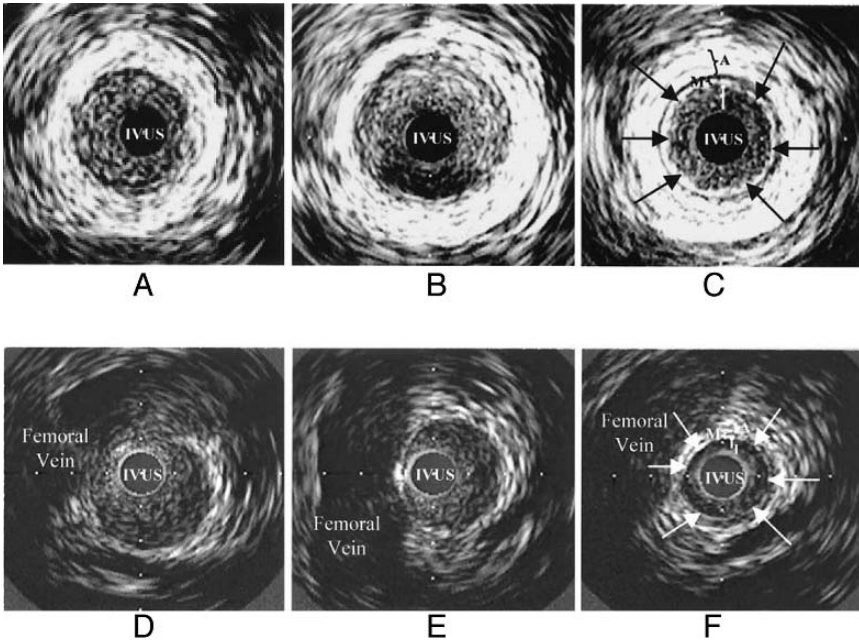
In vivo experiment demonstrating the attachment of anti-ICAM-1- and anti-VCAM-1-conjugated echogenic immunoliposomes to atherosclerotic arterial wall. Intravascular ultrasound imaging of the atherosclerotic left carotid artery of a Yucatan miniswine. A After injection of saline. B Five minutes after injection of unconjugated liposomes. C After injection of anti-ICAM-1-labeled liposomes (arrows point to enhanced atheroma). Intravascular ultrasound imaging of the atherosclerotic femoral artery of a Yucatan miniswine. D After injection of saline. E Five minutes after injection of unconjugated liposomes. F After injection of anti-VCAM-1-labeled liposomes (arrows point to enhanced atheroma). Reproduced with permission from Hamilton et al. (2004).
